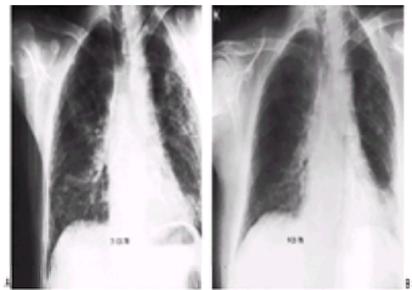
Bleomycin pneumonitis. A: Posteroanterior chest x-ray film showing bilateral interstitial infiltrates. Total dose of bleomycin was 360 mg during 8 weeks. B: Marked clearing after steroid therapy. (Reproduced with permission from Brown L, et al. Successful treatment of bleomycin lung. *Cleve Clin Q* 1980;47:99.)
